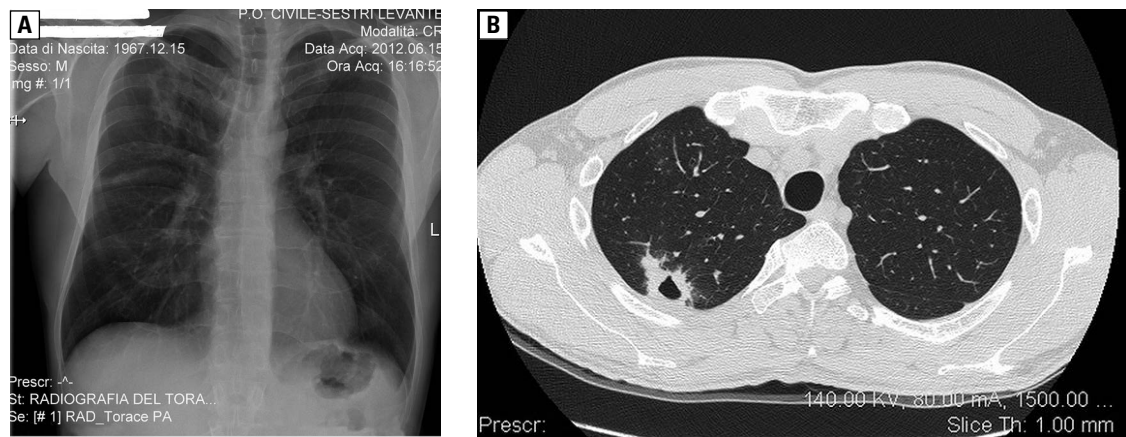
A — chest radiograph shows a right upper fluid-filled cavitation; B — chest computed tomography: spherical mass with air-fluid level (6.7×4.6 cm) at the level of the dorsal segment of the right upper lobe
